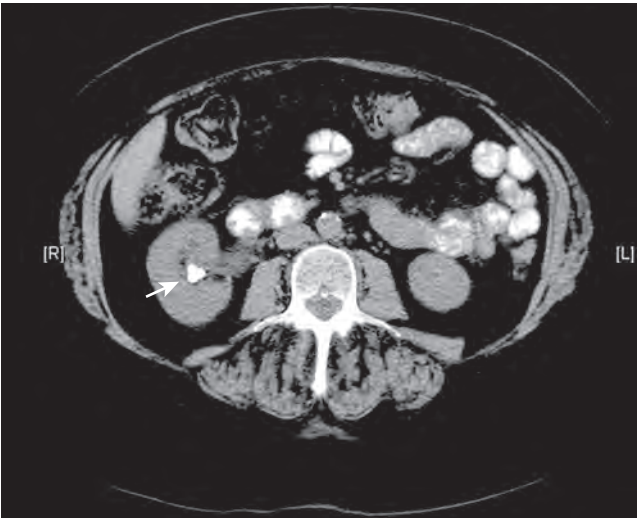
Computed tomography image of a urinary calculus. All stones (with the exception of some medication calculi) appear as dense, white objects (arrow) within the urinary collecting system.
